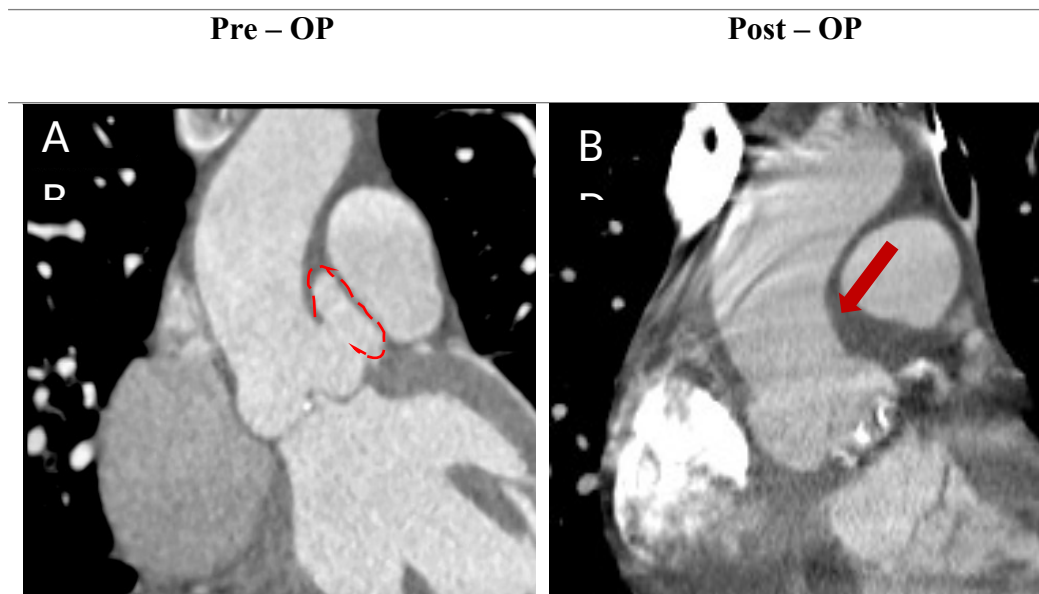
(A) Pre – OP CT scan showing large aneurysm of the Sinus of Valsalva.
